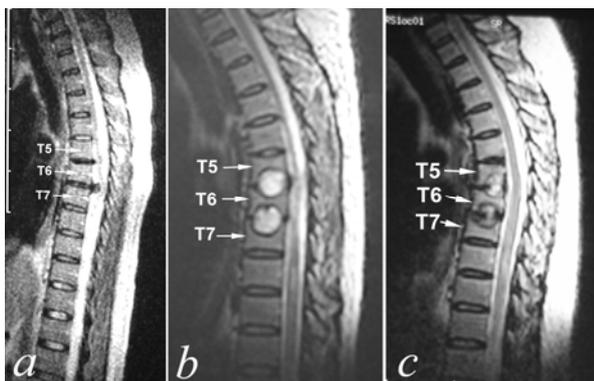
Sagittal MRI of the thoracic spine. a – preoperative MRI shows two-level disc herniations at T5/6 and T6/7 compressing the spinal cord; b – postoperative MRI shows complete removal of the herniated discs at T5/6 and T6/7; c – 1 year after the operation. T5/6 and T6/7 lesions had been adequately removed, the vertebral body resection sites shows prominent osseous regeneration. No signs of segmental kyphosis at the operated level.
